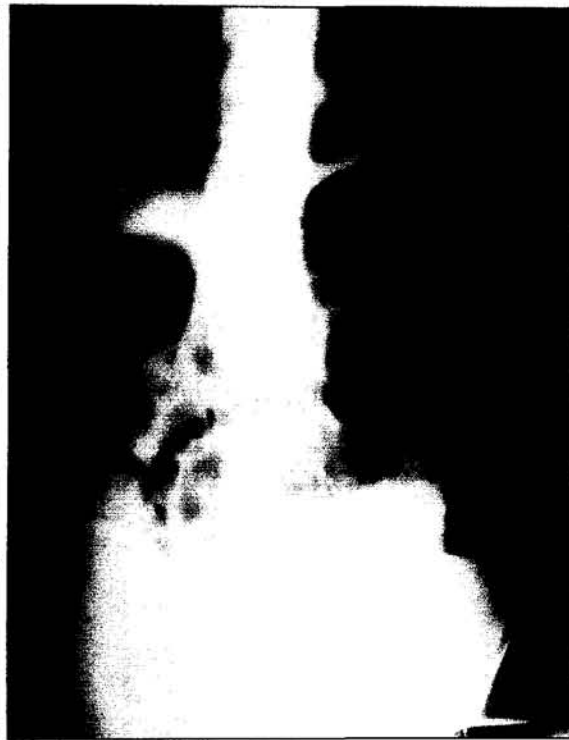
Erect abdominal x-ray
